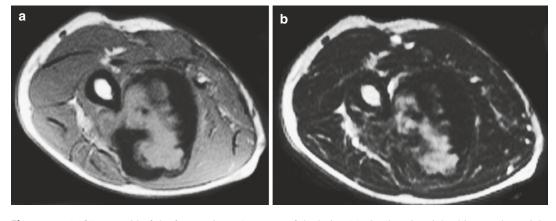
(a, b) Desmoid of the forearm in a 71-yearold man. (a) Axial spin-echo T1-weighted MR image. (b) Axial spin-echo T2-weighted MR image. On the T1-weighted image, there is a large mass at the volar aspect of the forearm adjacent to the interosseous membrane, with a rim of low signal intensity at the periphery
